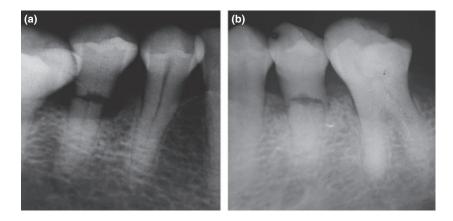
Radiograph of the mandibular right second premolar (a) and left second premolar (b) showing horizontal root fractures with surrounding bone loss.
